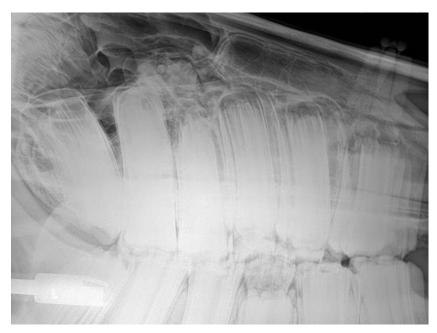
DR x-ray lateral view image.
